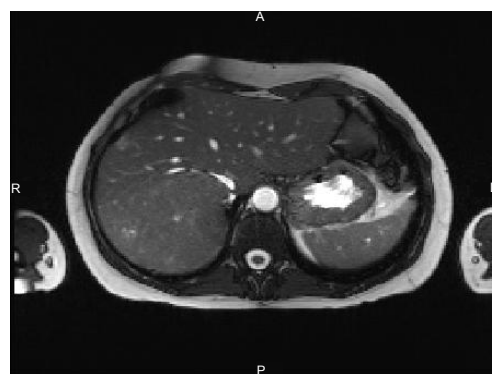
MRI T2, IVC compressive by the tumour.
